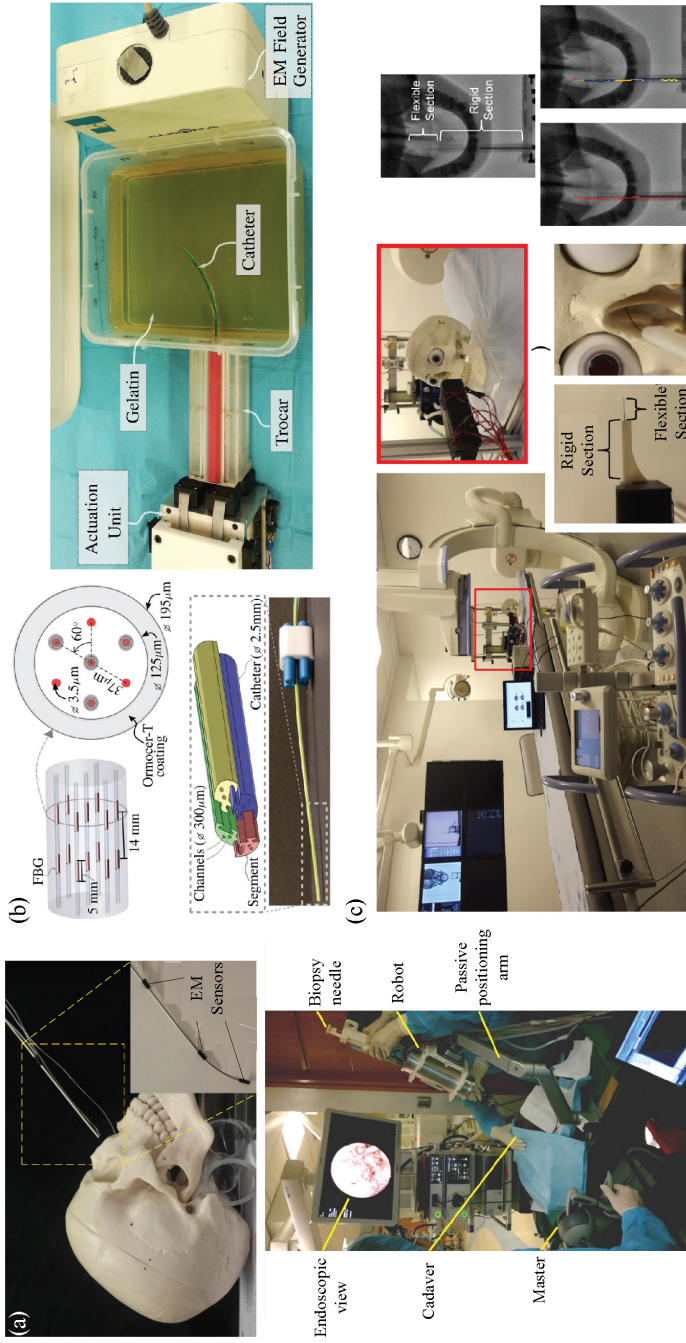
Shape sensing techniques for continuum manipulators in minimally invasive surgery: (a) Electromagnetic (EM)-based tracking of a continuum tubular robot for nasopharyngeal biopsy [54]. (b) Fiber Bragg gratings (FBG) sensors used for shape reconstruction of a catheter [55]. (c) Shape-sensing technique fusing X-ray fluoroscopy with the kinematics model of a concentric tube robot [56].
